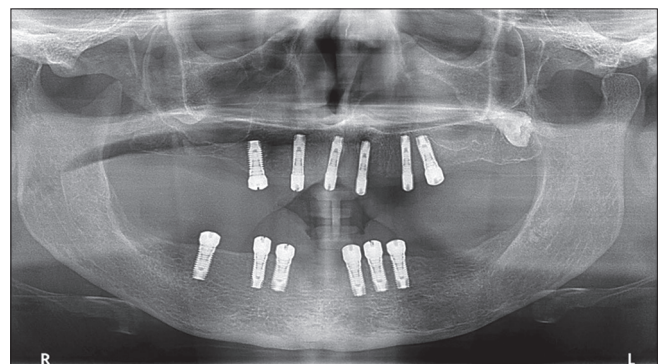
Radiographic presentation of patient before definitive prosthodontic treatment shows 6 implants in each arch with stable bone levels around all implants
